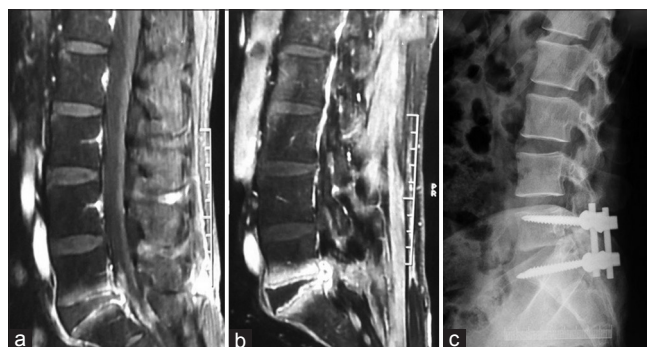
Gadolinium-enhanced T1-weighted fat suppressed the sagittal image of a follow-up case of L5-S1 discectomy showing (a) reduced L5-S1 intervertebral disc space with end plate irregularity and postcontrast enhancement. Mild enhancement also noted in overlying anterior and posterior epidural space. (b) After 6 weeks of intravenous antibiotic administration, follow-up scan demonstrated increase in the end plate and epidural contrast enhancement and marginal irregularity. Involvement of paraspinal soft tissue also noted. Decompression and L5-S1 transpedicular (c) fixation was done after 6 weeks of failed conservative treatment
